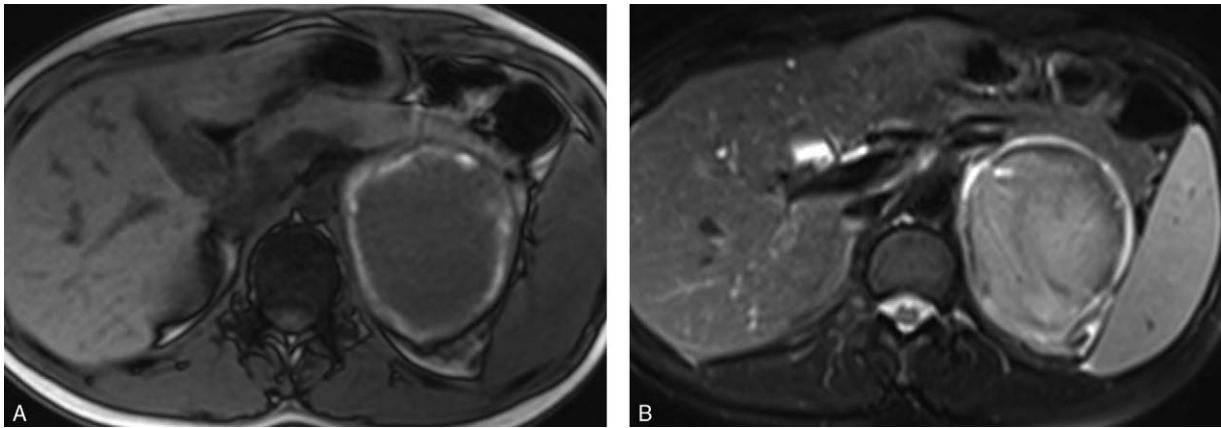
Unenhanced MR images at the 17 weeks of pregnancy. A, Axial T1-weighted image shows heterogeneous signal with a high-signal-intensity rim and slightly low-signal-intensity center. B, Axial fat-saturated T2-weighted image shows hypointense rim and slightly high signal center, and some mild edema in the fat space around the mass. MR=magnetic resonance.
